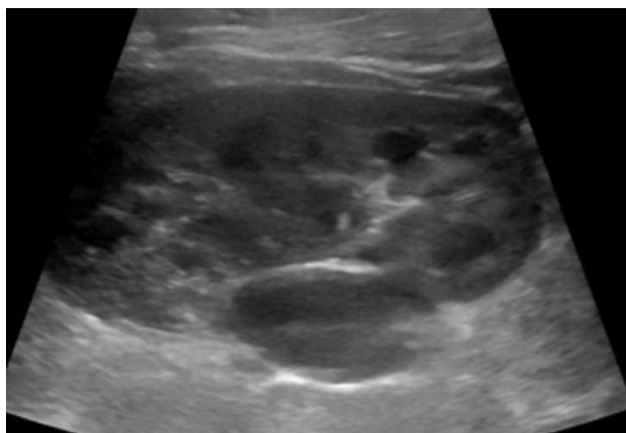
Ultrasound image of the patient's left kidney which was reported as normal but in proximity of a "fluid-filled structure" which did not appear to communicate with the renal collecting system.
